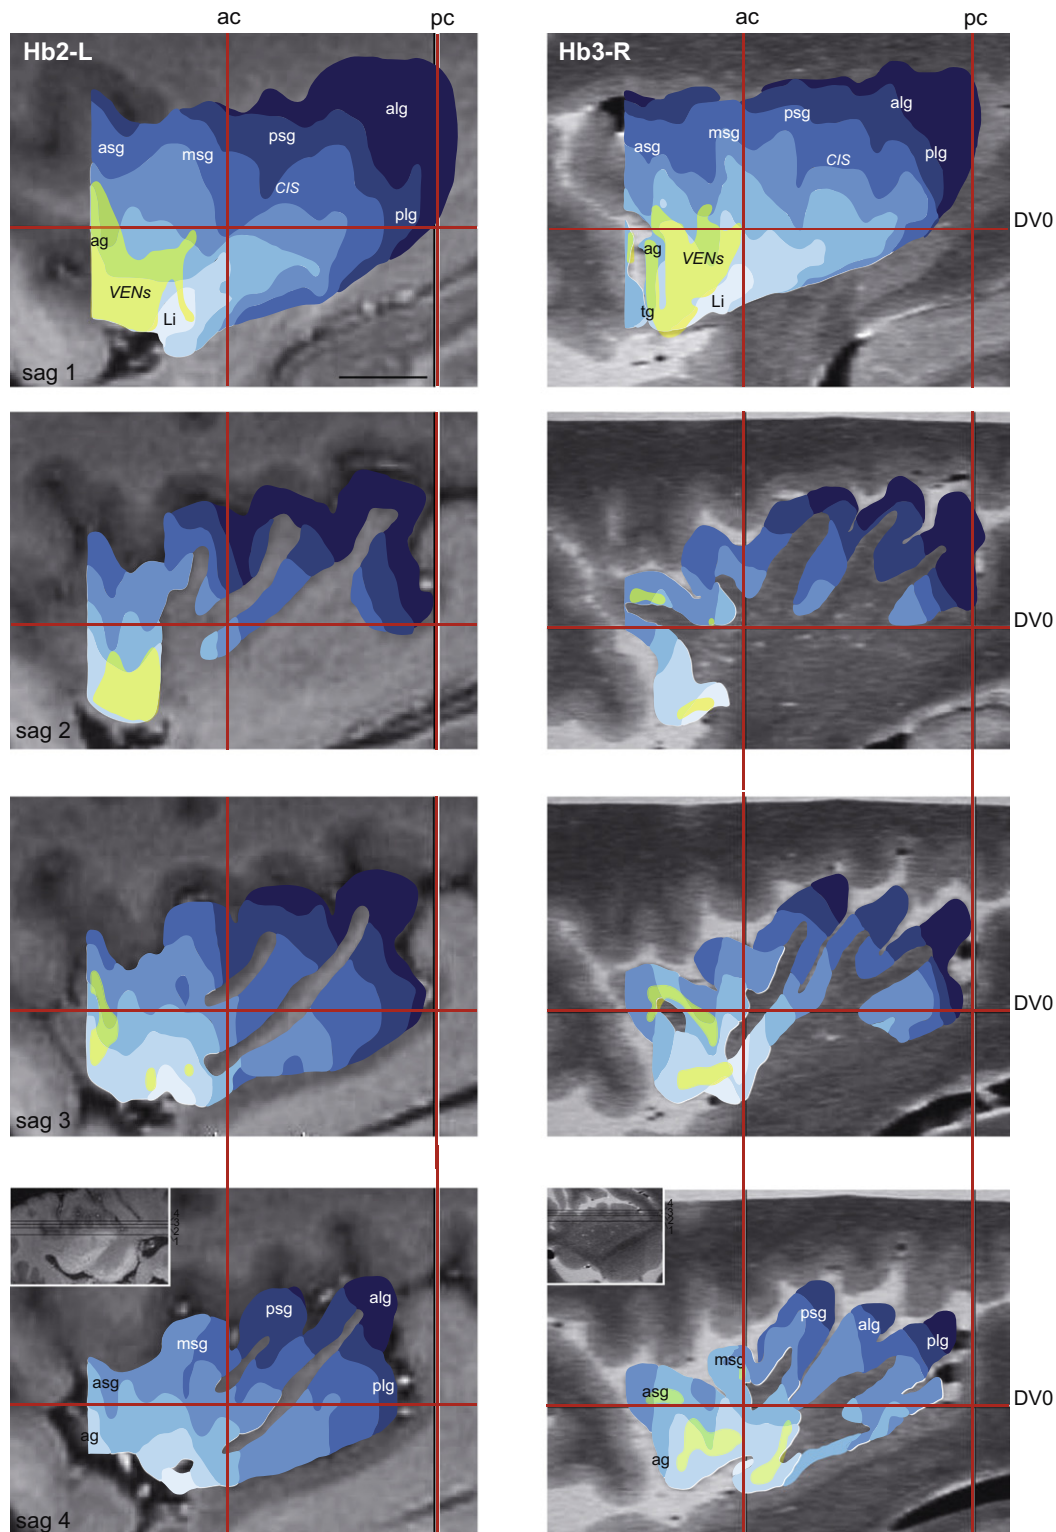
Sagittal MRI registrations of maps Hb2-L and Hb3-R. The cytoarchitectonic maps are registered to sagittal MRI (see levels in inset horizontal MRI in lower panels) and arranged from medial to lateral (sag 2–4). The distance between sagittal MRI 2–4 is smaller (1.5 mm) in the case of Hb3-R than in the case of Hb2-L (2.5 mm). A surface map projected onto more medial MRI (sag 1, upper panels) gives the full extent of the cytoarchitectonic subdivisions in relation to sulcal/gyral insular landmarks. Stereotactic planes are indicated in red. Scale bar (upper left panel) = 10 mm. Same color codes as in Figs. 3, 4 and 6. See list of abbreviations.
